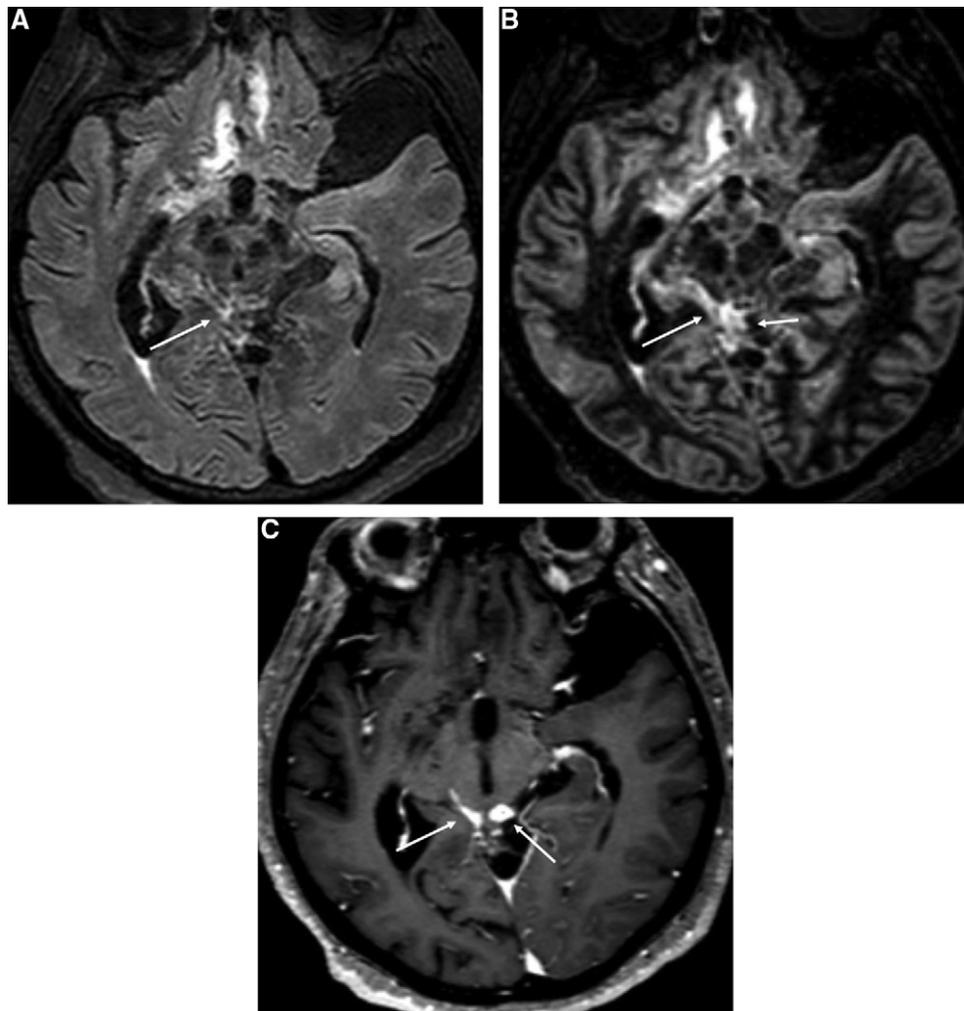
A 67-year-old woman with tuberculous meningitis examined using 3D FLAIR, 3D DIR, and contrast-enhanced 3D T1-weighted MR imaging. (A) 3D FLAIR, (B) 3D DIR and (C) contrast-enhanced 3D T1-weighted MR images showing tuberculous meningitis. Without contrast medium, 3D DIR imaging can detect leptomenigeal lesions more clearly than 3D FLAIR imaging (arrows A–C).
